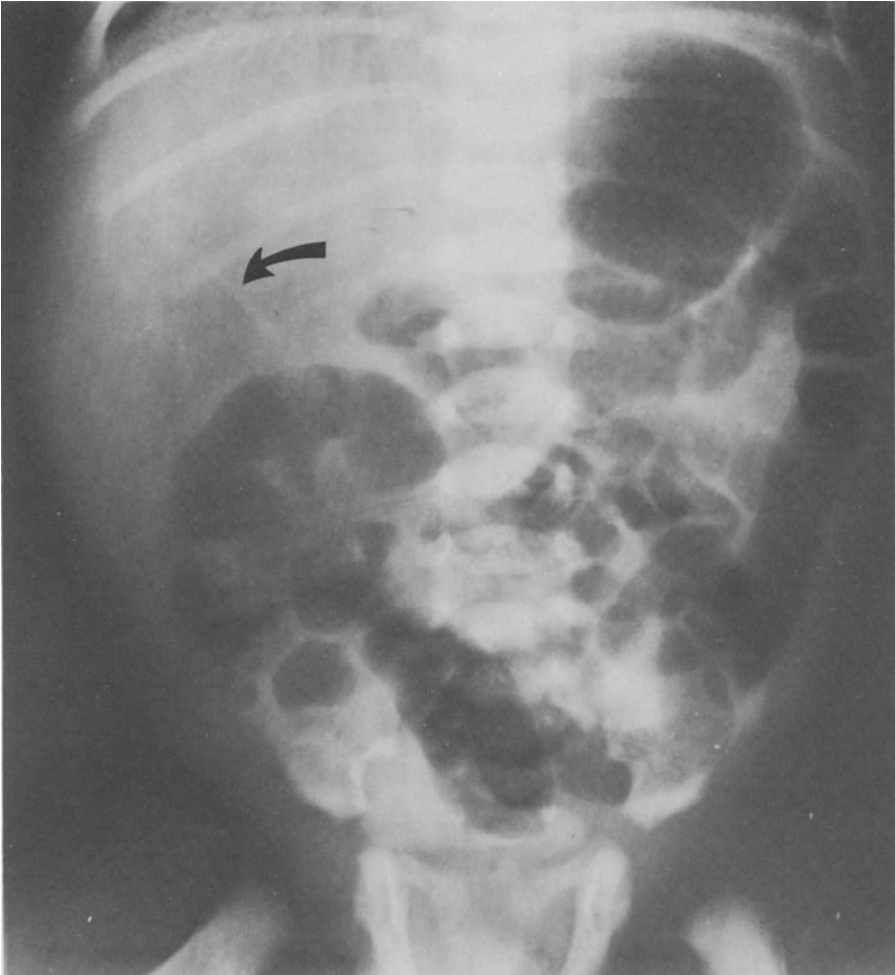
Posteroanterior radiograph of an intravenous urogram at 10 minutes in a neonate with a right flank mass. A vague relative lucency is noted in the area of the right renal fossa with a dense line within (arrow) representing a cyst wall in a case of multicystic dysplastic kidney. The left kidney was shown to be normal on subsequent films and there was no function demonstrated on the right side as late as 24 hours postinjection.
